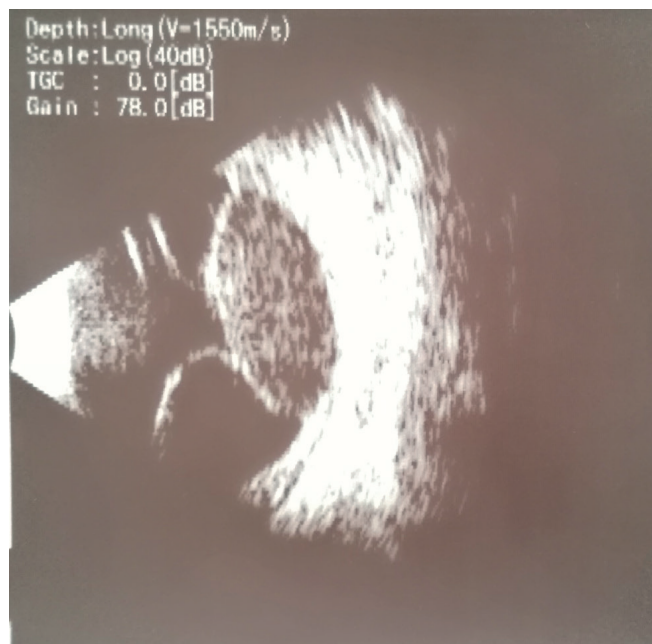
Ultrasound of right eyeball – nearly total retinal detachment (apart from small area above), solid lesion with smooth surface with low internal reflectivity in temporal periphery
